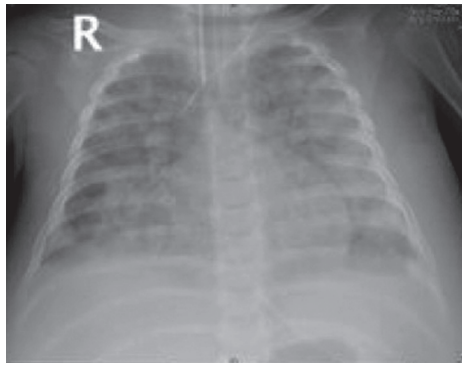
Chest x-ray with bilateral chest infiltration in a 9-month-old child.
